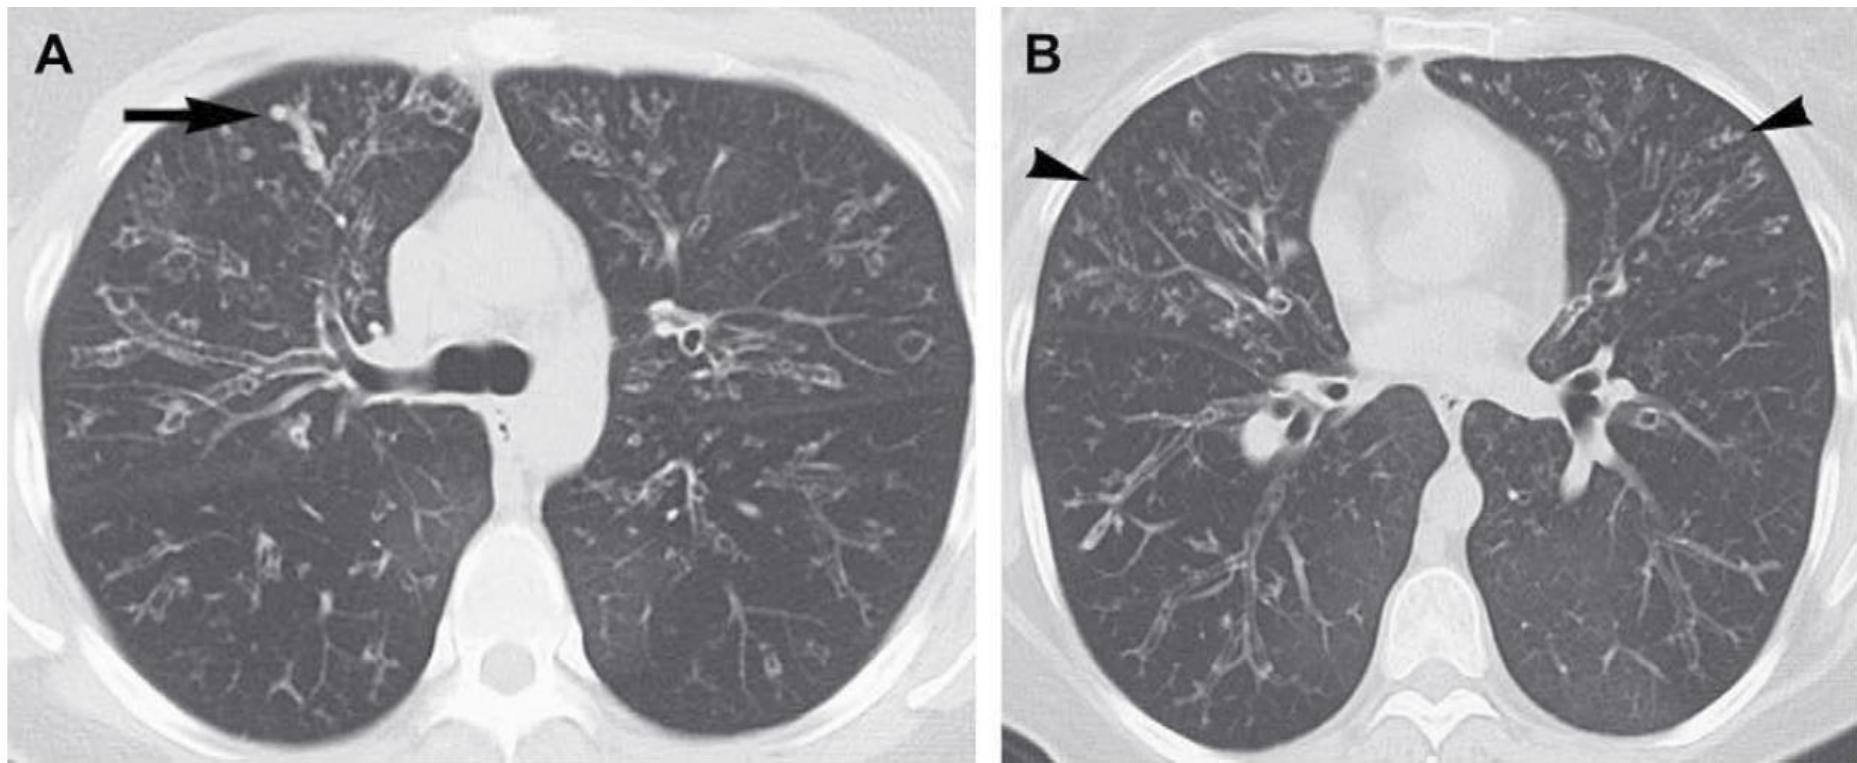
Mucus plugging on CT. On transaxial images, the filling of bronchiectasis by mucus appears as tubular and branching opacities, with club-like, rounded ends (arrow) (A). The mucus-filled smaller branching bronchi and bronchioles appear as tree-in-bud opacities (arrowheads) (B). The mosaic attenuation of the surrounding lung is due to air trapping. In this case, the bronchiectasis was from cystic fibrosis.
